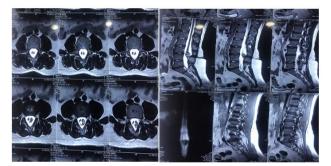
MRI showing Diastematomyelia due to Spinal intradural Extramedullary Teratoma.
